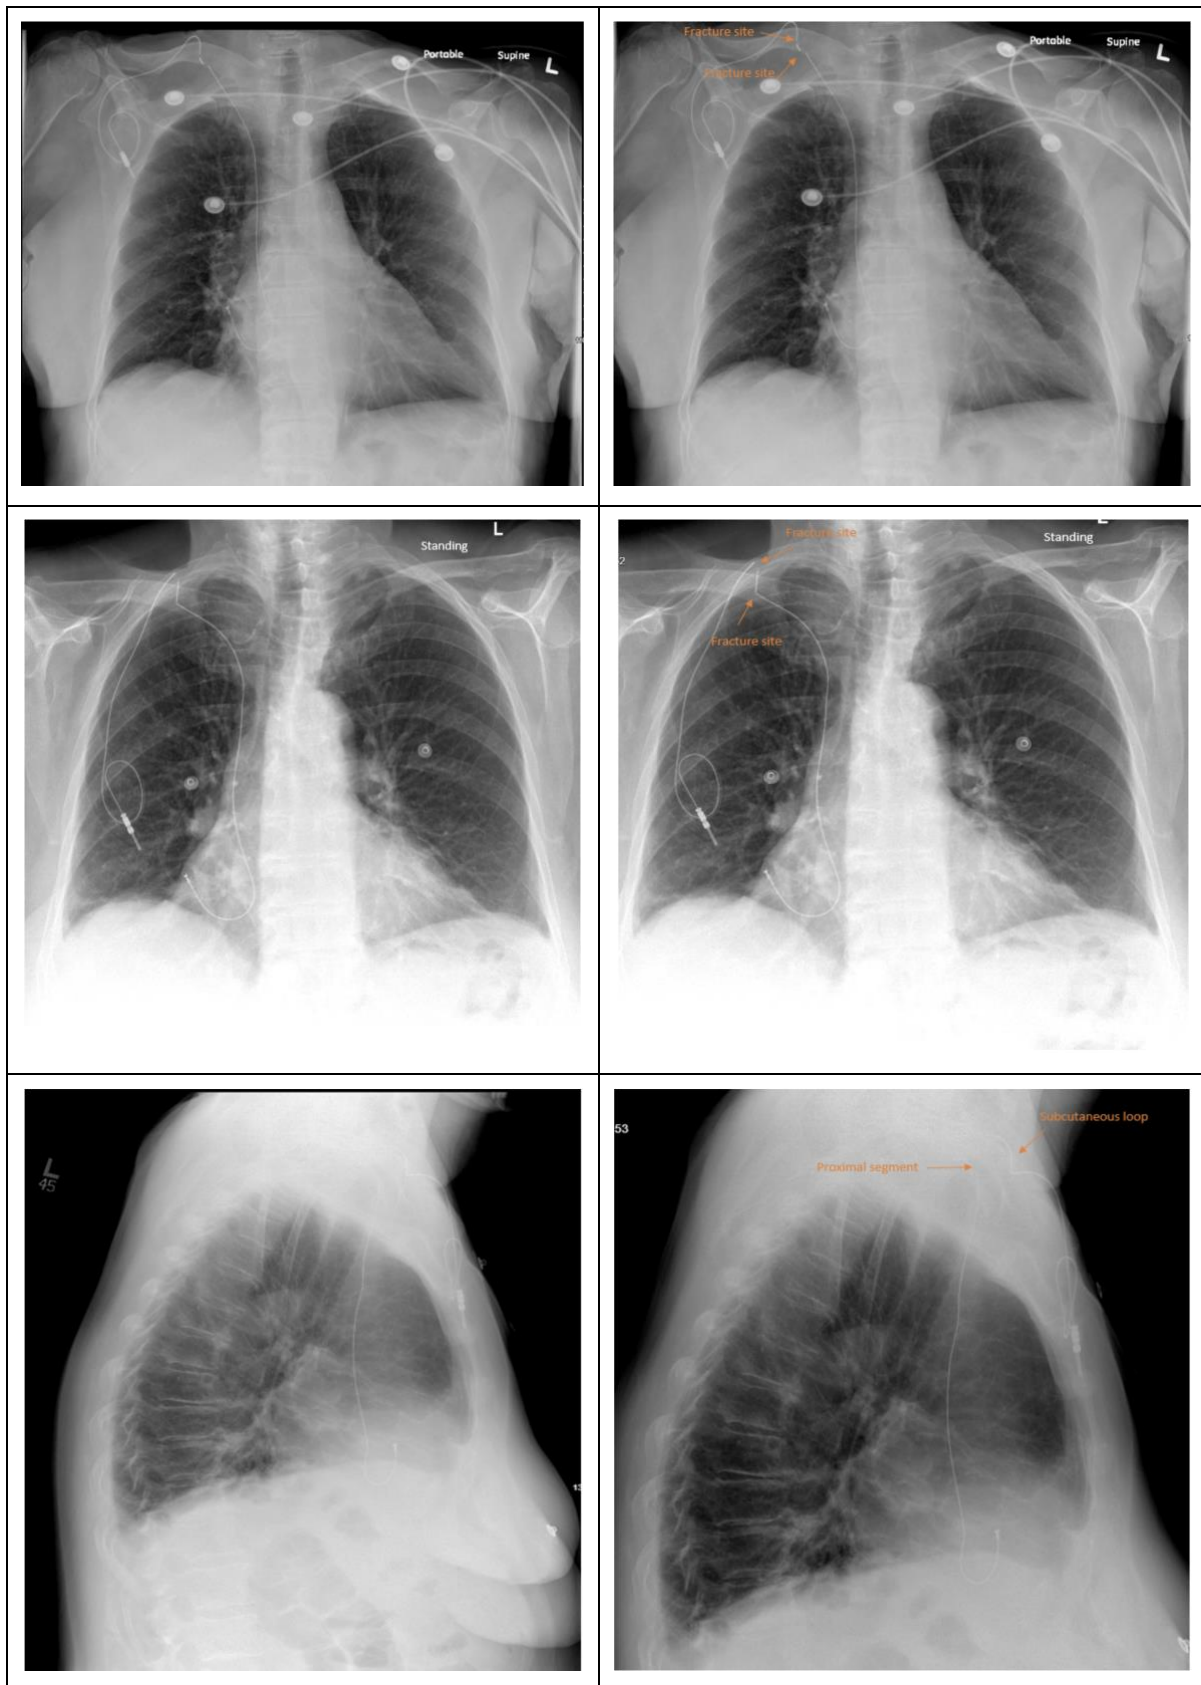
Supine and standing anteroposterior (AP) and lateral chest radiographs showing a retained epicardial pacemaker lead with two distinct fracture sites. On the labelled supine AP image, the distal segment is looped subcutaneously over the right second and third anterior ribs, while the proximal fragment projects inferiorly toward the cardiac silhouette. The generator is absent. The retained structure represents a single electrode, most likely the atrial lead.
